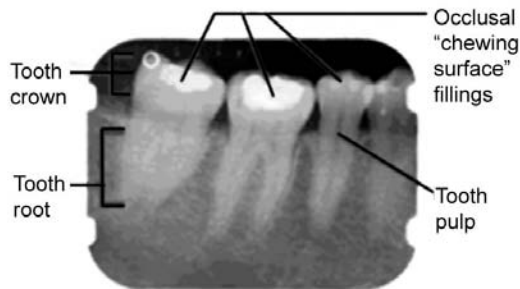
Parts of the tooth to be assessed radiographically
